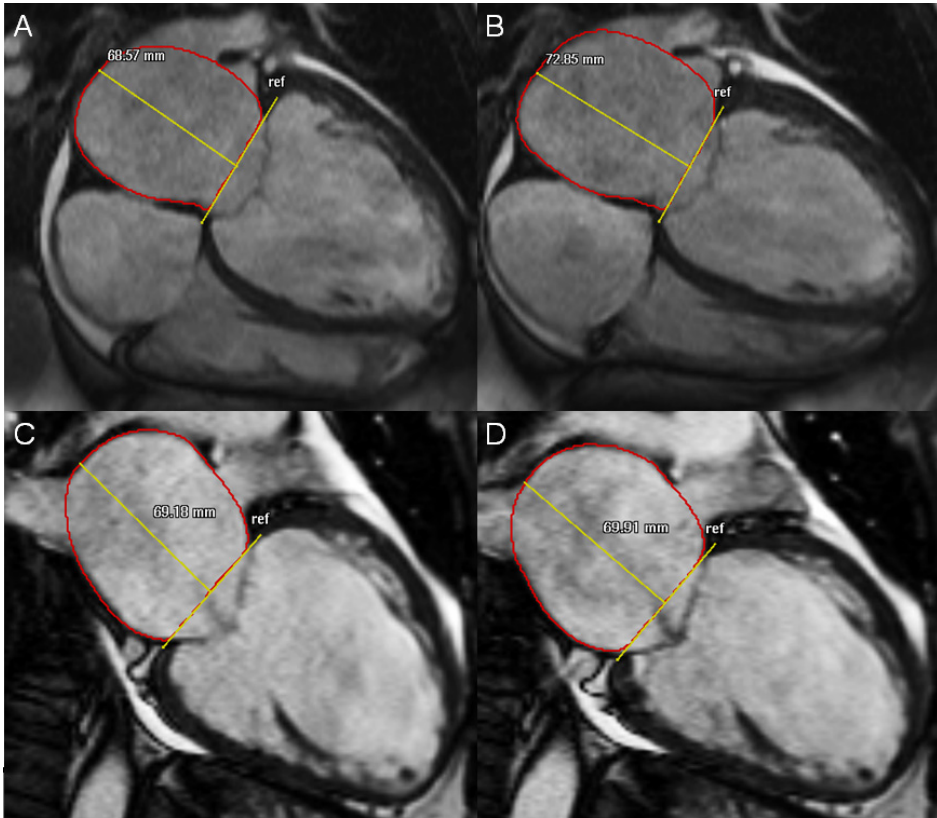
Example of CMR evaluation of the maximum and minimum left atrial volumes using the biplane area-length method in the apical four-chamber view (A, B) and two-chamber view (C, D). CMR, cardiovascular magnetic resonance imaging; LA, left atrium.
